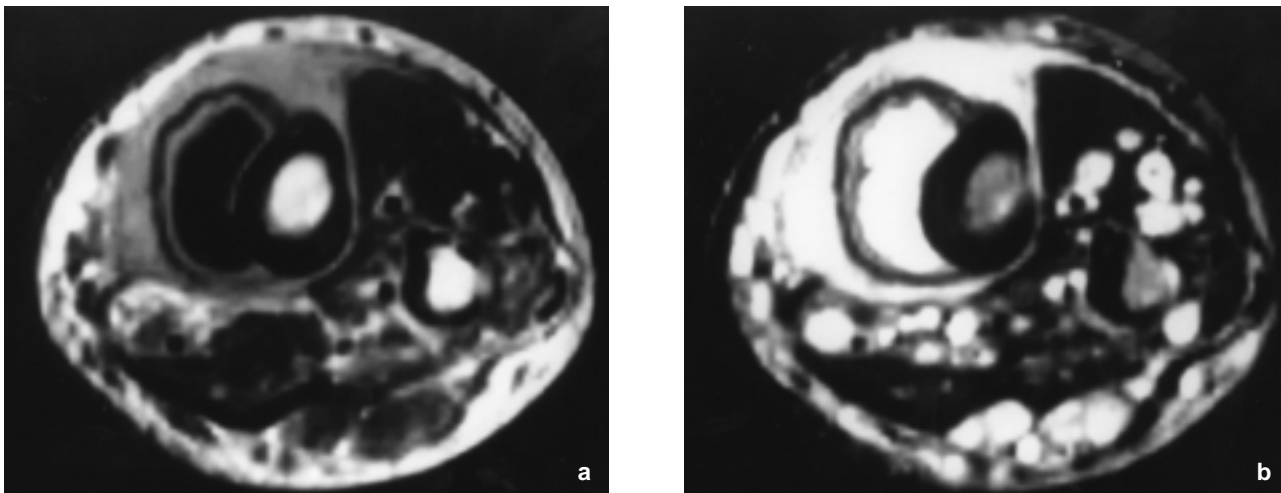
MRI of the left lower leg (axial T1-weighted (a) and T2-weighted image).
